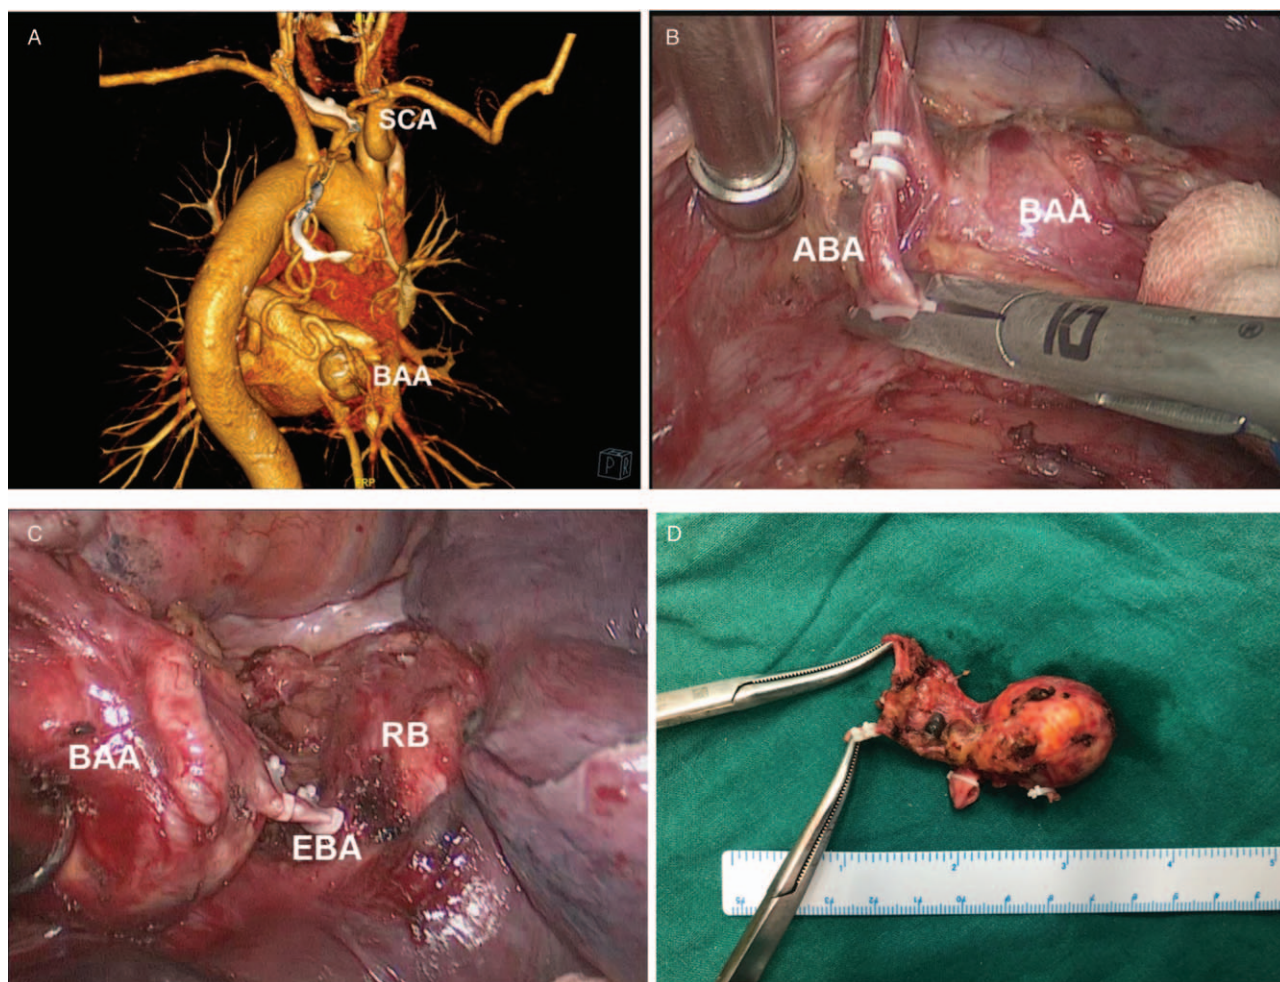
Representative image of the patient. (A) Three-dimensional computed tomography (CT) shows the bronchial artery aneurysm (BAA) location and a tortuous afferent bronchial artery originating from the right subclavian artery. (B) Afferent branches of the BAA were ligated. (C) The efferent branch of the BAA was ligated. (D) The aneurysm was completely resected. SCA: Subclavian artery; BAA: Bronchial artery aneurysm; ABA: Afferent bronchial artery; EBA: Efferent bronchial artery; RB: Right bronchus.
